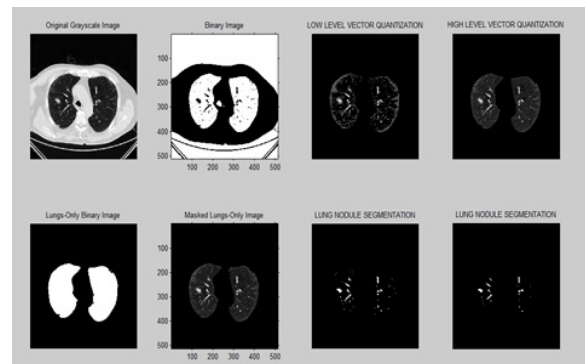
Abnormal lung CT images
